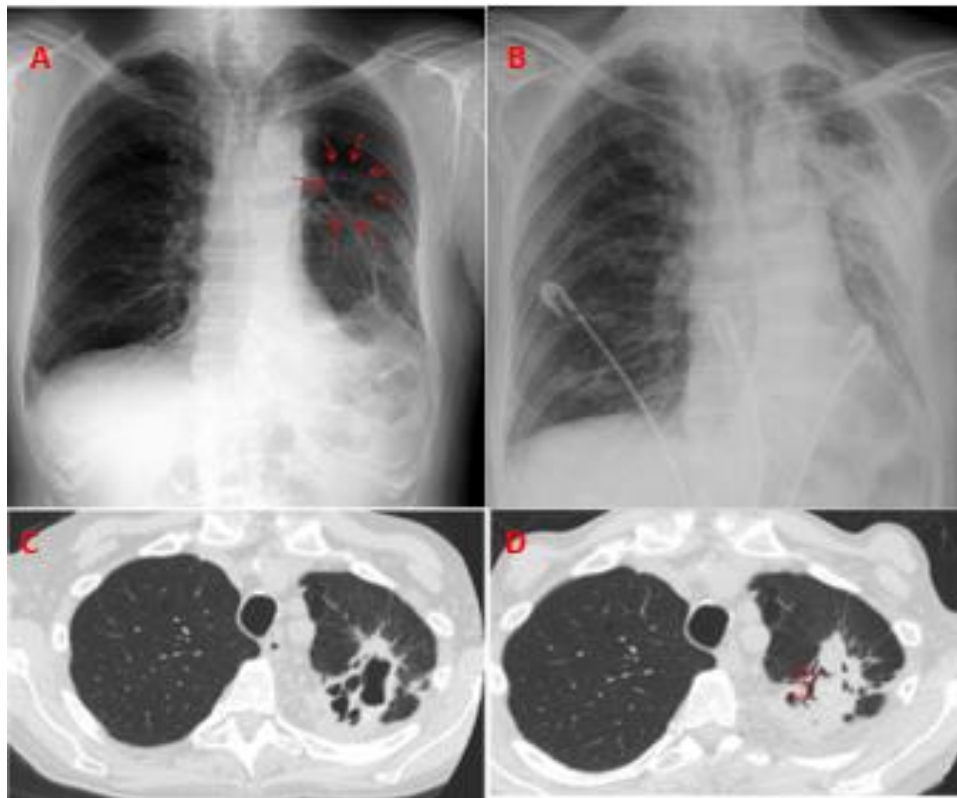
Conventional Chest X-Ray and CT of Aspergilloma.
